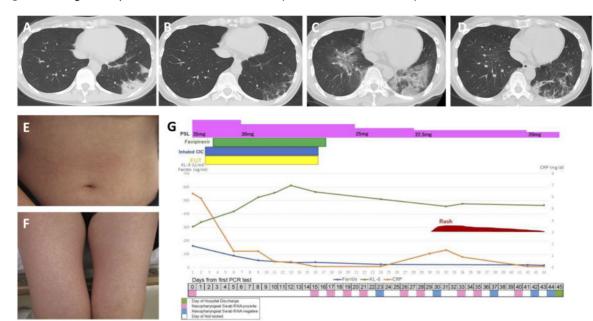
CT images and post-admission course in 2020 (coronavirus disease 2019)
